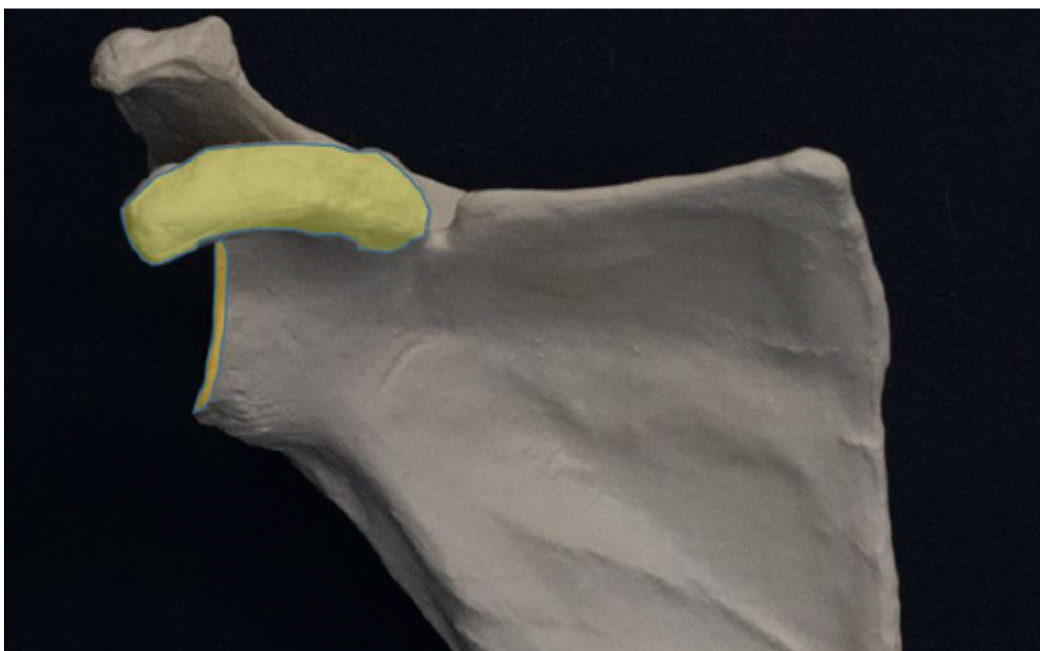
Note the difference in orientation of the glenoid (*orange*) in profile and the coracoid process (*yellow*), as well as their radiographic representation with a Grashey AP view.
